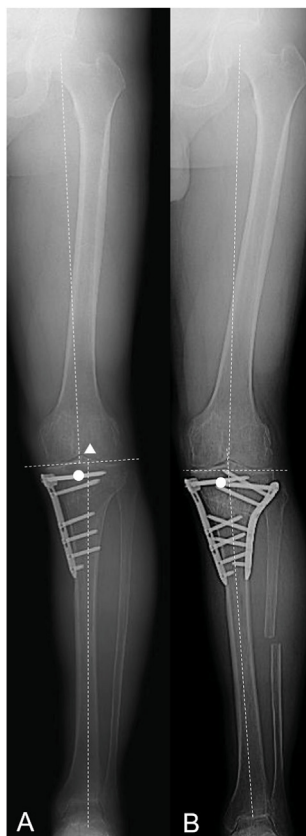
Re-correction HTO (Case 2 in Table 1). A. Full-length anteroposterior radiograph 3 years after the primary HTO indicates undercorrection (HKA angle of -4° [angle between the two vertical dashed lines]) due to the remaining medial tibial tilt (mMPTA of 85° [white circle]) without femoral deformity (mLDFA of 87° [white triangle]). B. Full-length anteroposterior radiograph after closed-wedge HTO conversion shows the sufficiently corrected limb alignment (HKA angle of 5° and mMPTA of 93° [white circle]). HTO, high tibial osteotomy; HKA angle, hip-knee-ankle angle; mMPTA, mechanical medial proximal tibial angle; mLDFA, mechanical lateral distal femoral angle.
